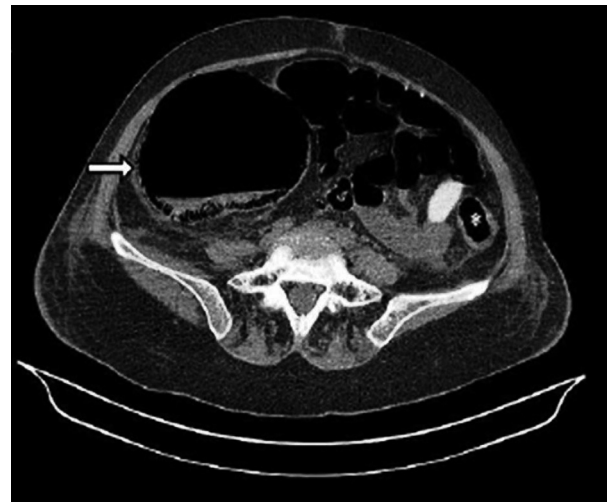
Abdominal CT image showing marked cecal dilatation.
